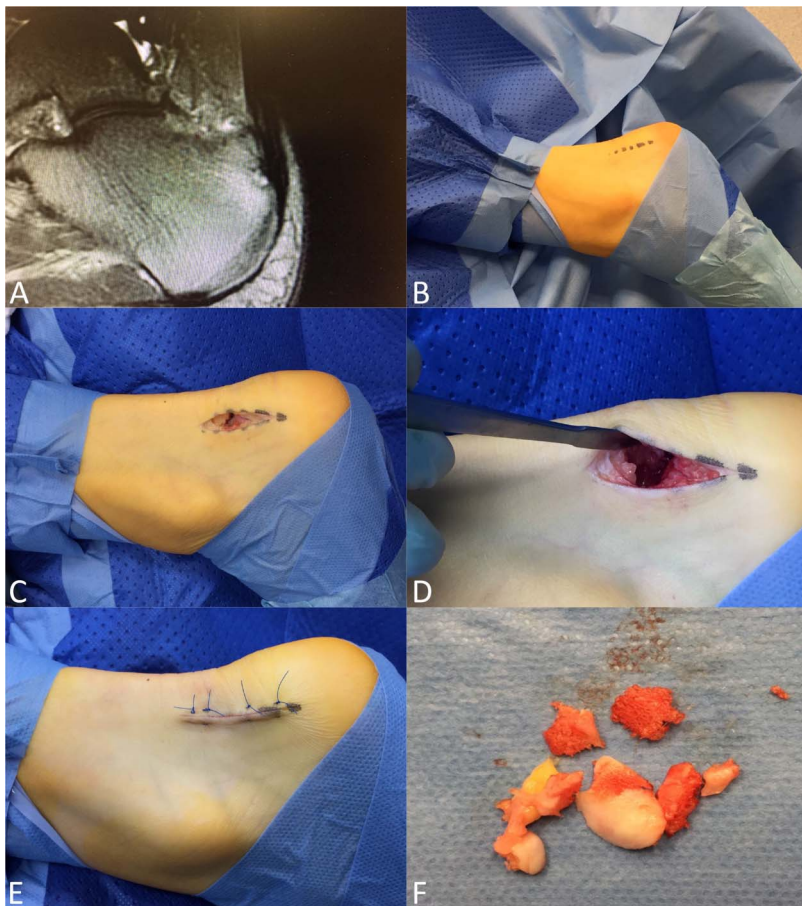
Perioperative images of EPCC using a posterolateral para-Achilles tendon incision: (A) preoperative MRI; (B) marking of the planned skin incision; (C) skin incision and a single longitudinal lateral para-Achilles tendon incision was made, exposing the Achilles tendon insertion; (D) the posterosuperior corner of the calcaneus is visualized and resected that the calcaneal bone did not come into contact with the anterior aspect of the Achilles tendon during dorsiflexion of the ankle; (E) simple mattress sutures for wound closure; and (F) the excised bony parts.
